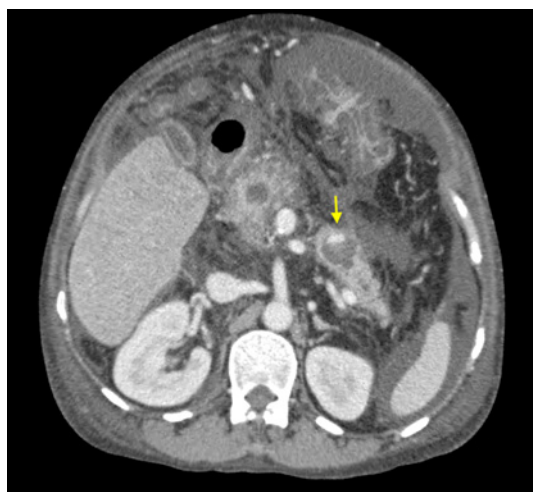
Contrast-enhanced computed tomography shows a pseudoaneurysm in the pancreatic pseudocyst.
